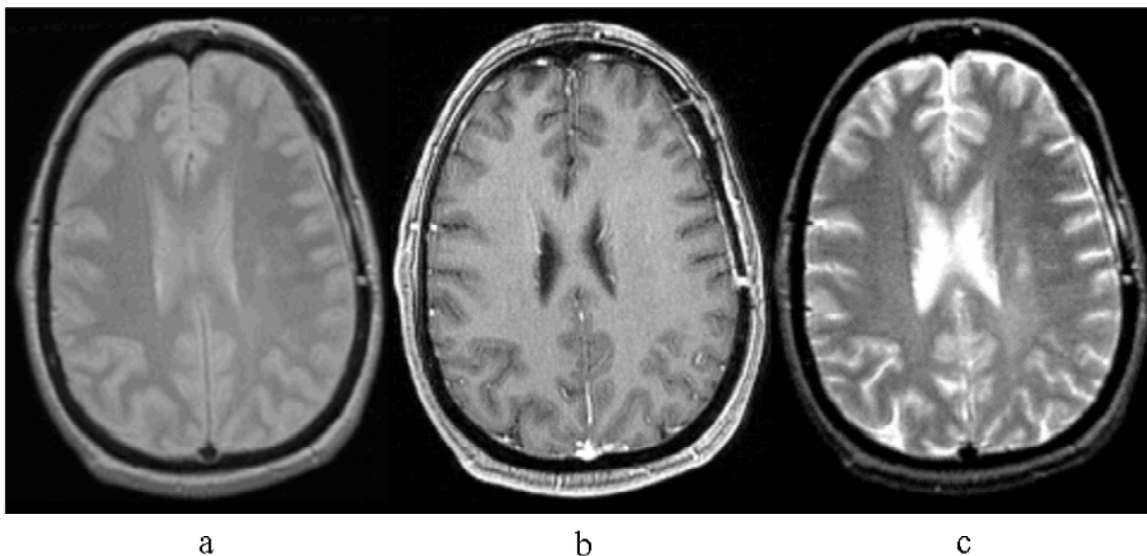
Example proton density (a), T1 (b) and T2 (c) weighted MR images.
